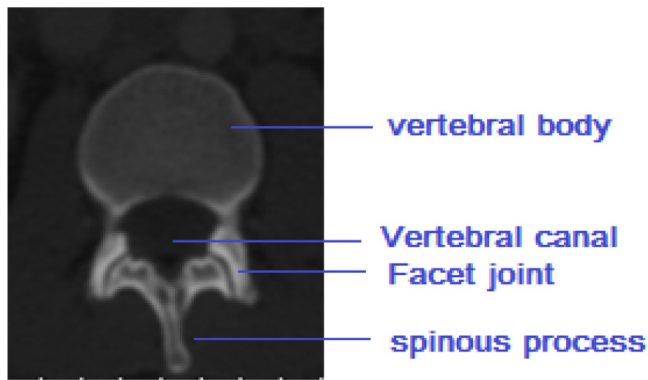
Vertebral canal in CT reconstruction.
